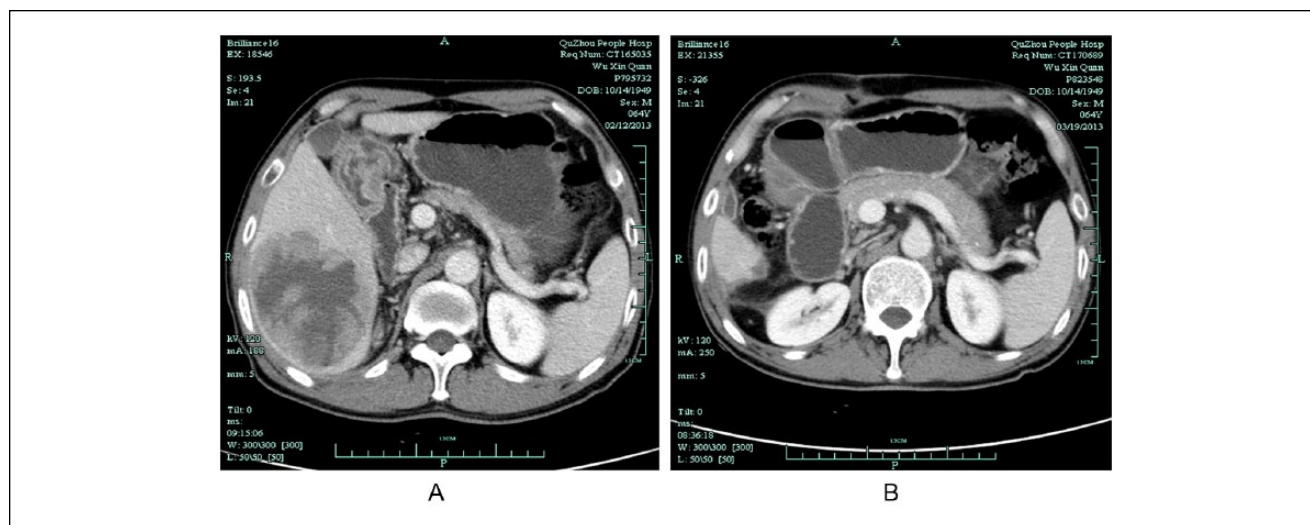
Computed tomography findings before and after surgery. (A) An enlarged solid mass in right lobe of liver on February 11, 2013. (B) CT scan after tumor resection on March 18, 2013.
